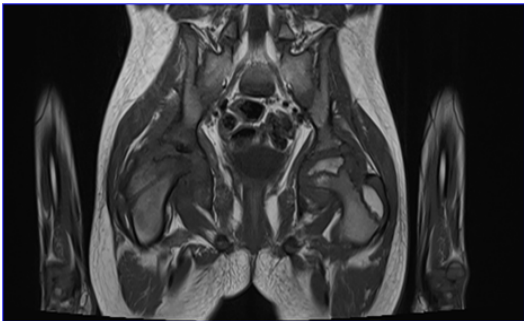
T1WI coronal MRI of a male child showing damage of the cartilage with edema and lysis of the bilateral femoral head-Septic arthritis.
